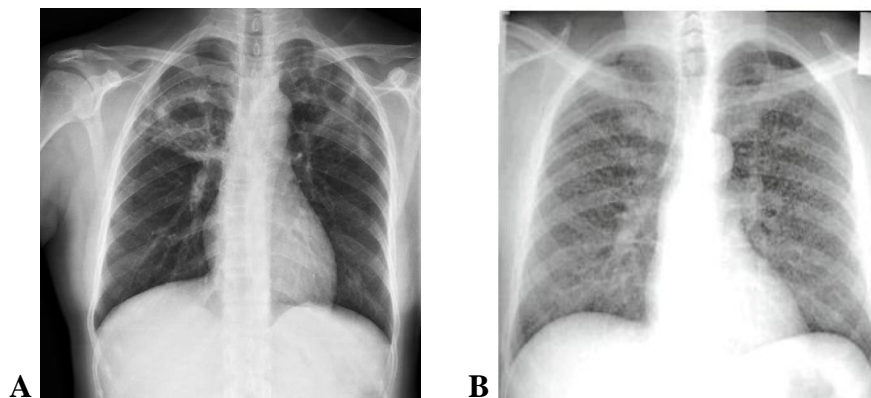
(A) This frontal chest radiograph demonstrates multiple cavitary lesions with relatively thick walls in the upper lobes. The patient suffered from reactivation tuberculosis. (B) This frontal chest radiograph has innumerable tiny opacities throughout both lungs, secondary to miliary tuberculosis
